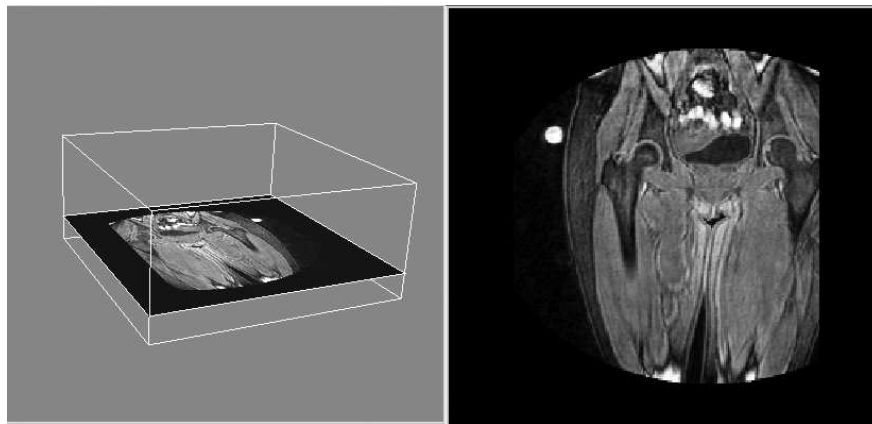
Sequential MRI protocol for bone motion analysis
